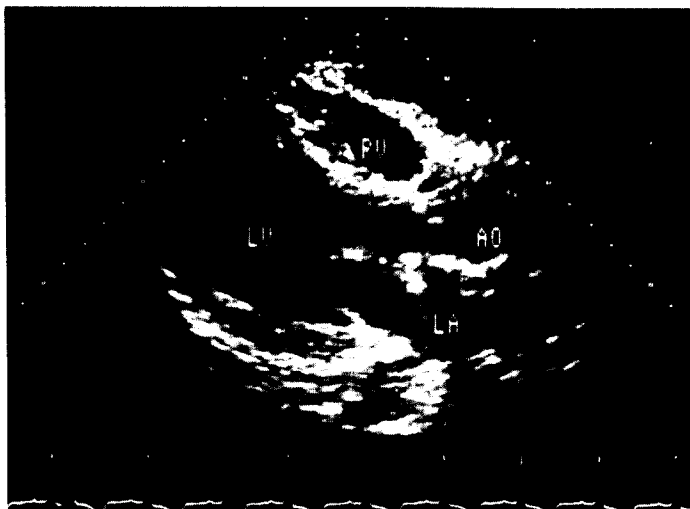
Preoperative echocardiogram.
